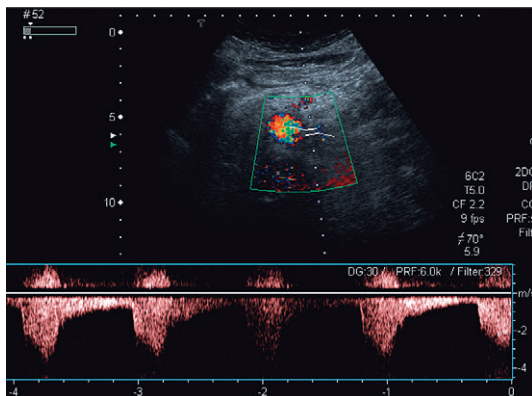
Left renal artery Doppler demonstrating increased systolic flow velocity in excess of 2 m s⁻¹ but reduced diastolic flow and consequent increased resistance index.
